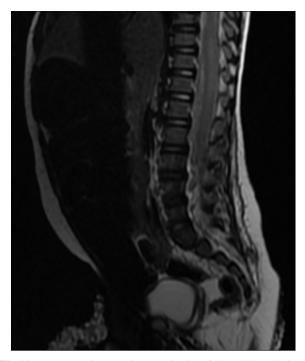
T2 MRI spine Saggital-showingdorsal dermal sinus.
